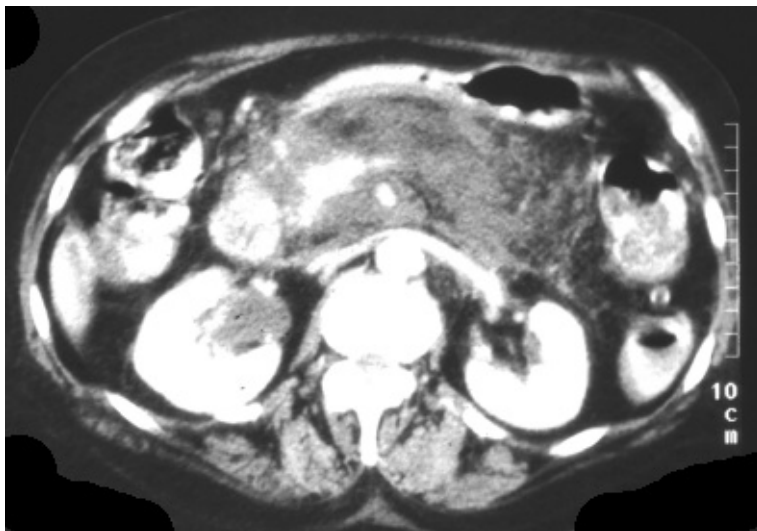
CT appearances of acute pancreatitis
